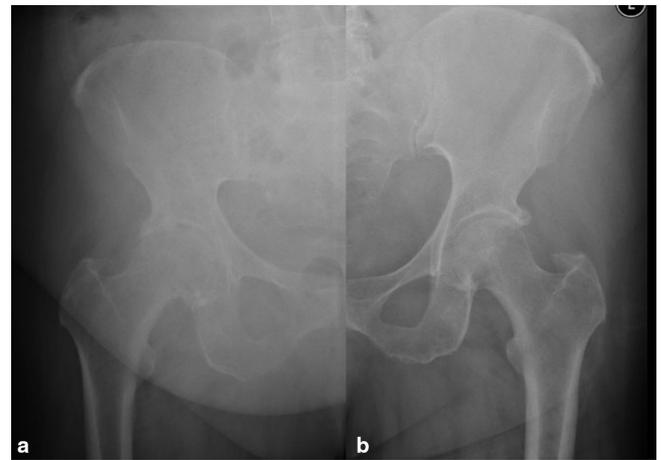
Paired radiographs of a 50-year-old female (a - erect, b - supine) with normal BMI. Note the organ displacement evidenced by the position of an intrauterine contraceptive device (small arrows). BMI, body mass index.
